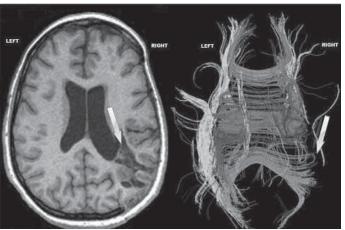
MRI T1 images and MRI tractography in a PVS patient with postanoxic encephalopathy after near drowning
